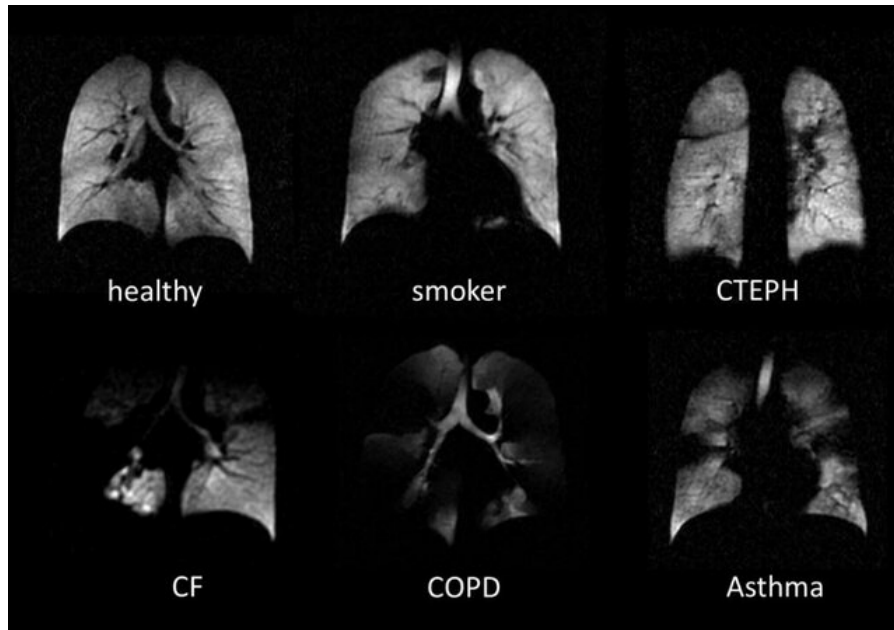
^3He lung MRI in a healthy volunteer and different subjects with smoking habits, chronic thromboembolic pulmonary hypertension (CTEPH), cystic fibrosis (CF), chronic obstructive pulmonary disease (COPD), and asthma.⁵⁶ Poorly ventilated areas, i.e. regions the gas does not reach, appear hypointense.
